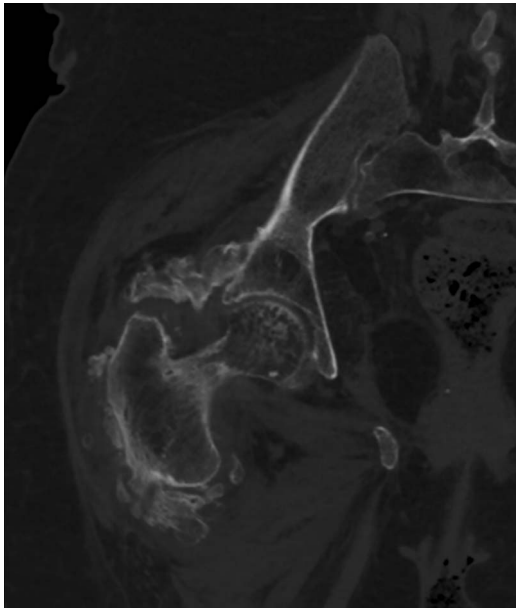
Axial CT demonstrates calcification within the soft tissue extending from the right acetabulum and ischium medially, to the proximal femur laterally.
